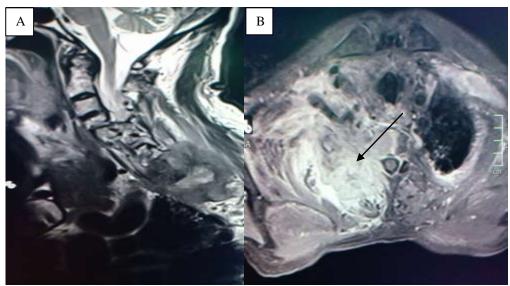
MRI of the right brachial plexus: sagittal (A) and axial (B) sequences showing diffuse enlargement with marked T2 hyperintensity of the right brachial plexus.
